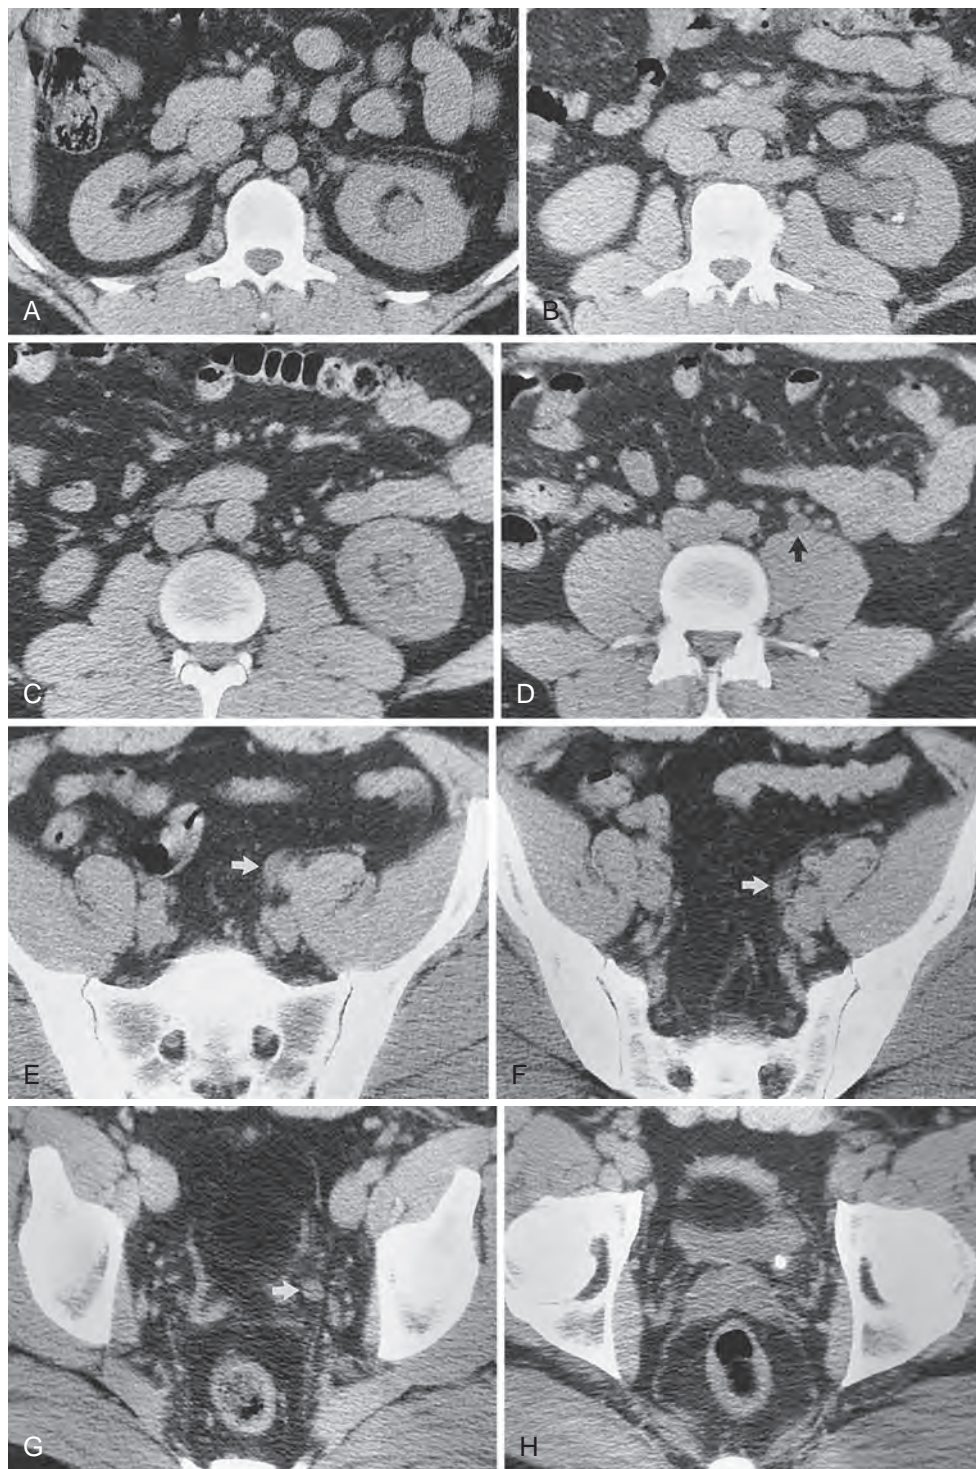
Computed tomography of the abdomen and pelvis in patient with an obstructing ureteral stone at the level of the ureterovesical junction (UVJ). A, Level of the left upper pole. Mild renal enlargement, caliectasis, and perinephric stranding are apparent. B, Level of the left renal hilum. Left pyelectasis with a dependent stone, mild peripelvic and perinephric stranding, and a retroaortic left renal vein are shown. C, Level of the left lower pole. Left caliectasis, proximal ureterectasis, and mild periureteral stranding are present. D, Level of the aortic bifurcation. The dilated left ureter (*arrow*) has lower attenuation than do nearby vessels. E, Level of the upper portion of the sacrum. A dilated left ureter (*arrow*) crosses anteromedial to the common iliac artery. F, Level of the midsacrum. A dilated left ureter (*arrow*) is accompanied by periureteral stranding. G, Level of the top of the acetabulum showing a dilated pelvic portion of the left ureter (*arrow*). H, Level of the UVJ. The impacted stone with a “cuff” or “tissue rim” sign that represents the edematous wall of the ureter. (From Talner LB, O’Reilly PH, Wasserman NF. Specific causes of obstruction. In: Pollack HM, McClennan BL, Dyer R, et al, editors. Clinical urography. 2nd ed. Philadelphia: Saunders; 2000.)
